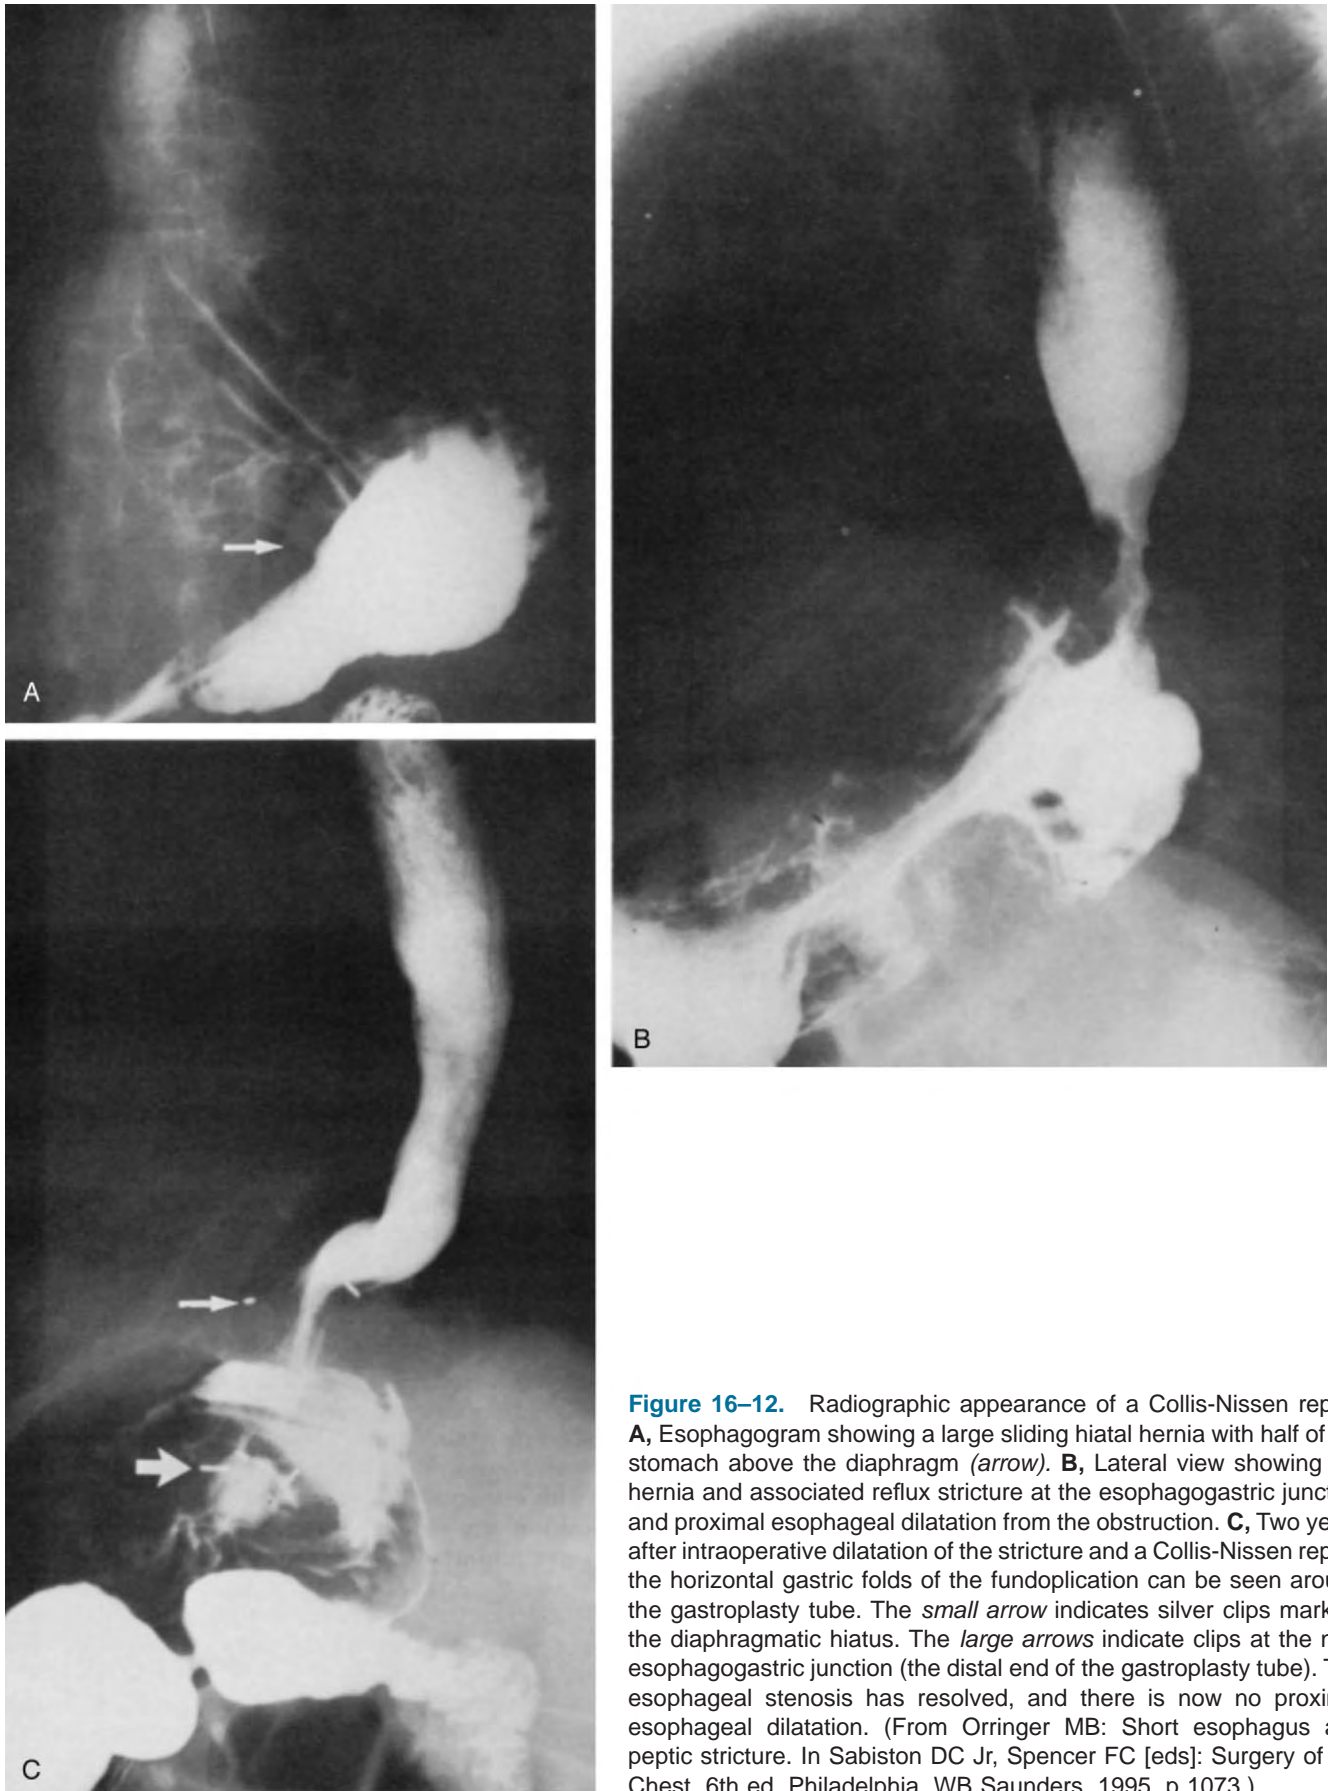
Radiographic appearance of a Collis-Nissen repair. A, Esophagogram showing a large sliding hiatal hernia with half of the stomach above the diaphragm (*arrow*). B, Lateral view showing the hernia and associated reflux stricture at the esophagogastric junction and proximal esophageal dilatation from the obstruction. C, Two years after intraoperative dilatation of the stricture and a Collis-Nissen repair, the horizontal gastric folds of the fundoplication can be seen around the gastroplasty tube. The *small arrow* indicates silver clips marking the diaphragmatic hiatus. The *large arrows* indicate clips at the new esophagogastric junction (the distal end of the gastroplasty tube). The esophageal stenosis has resolved, and there is now no proximal esophageal dilatation. (From Orringer MB: Short esophagus and peptic stricture. In Sabiston DC Jr, Spencer FC [eds]: *Surgery of the Chest*, 6th ed. Philadelphia, WB Saunders, 1995, p 1073.)
